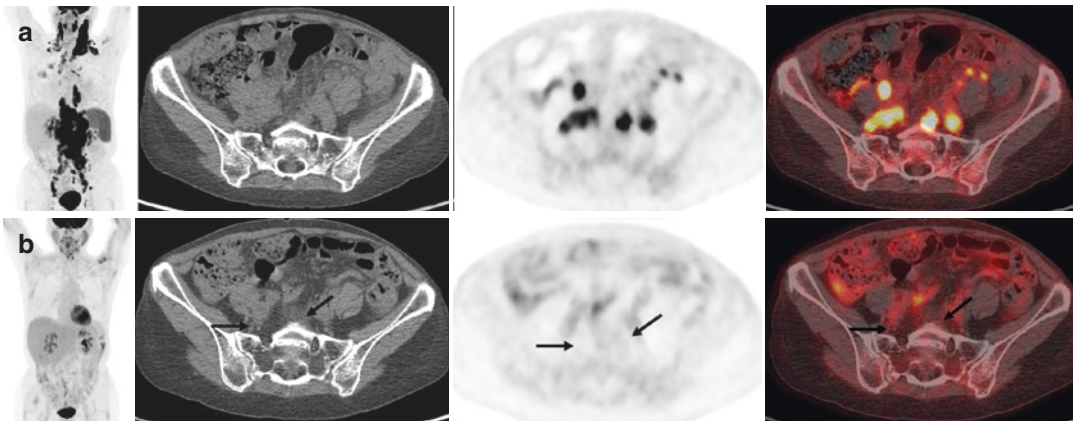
60-year-old woman with diffuse large B cell lymphoma. (a) Baseline FDG-PET/CT scans showed intensely FDG-avid lymphadenopathy above and below the diaphragm and moderately increased FDG uptake diffusely in the spleen. (b) After 6 cycles of R-CHOP
